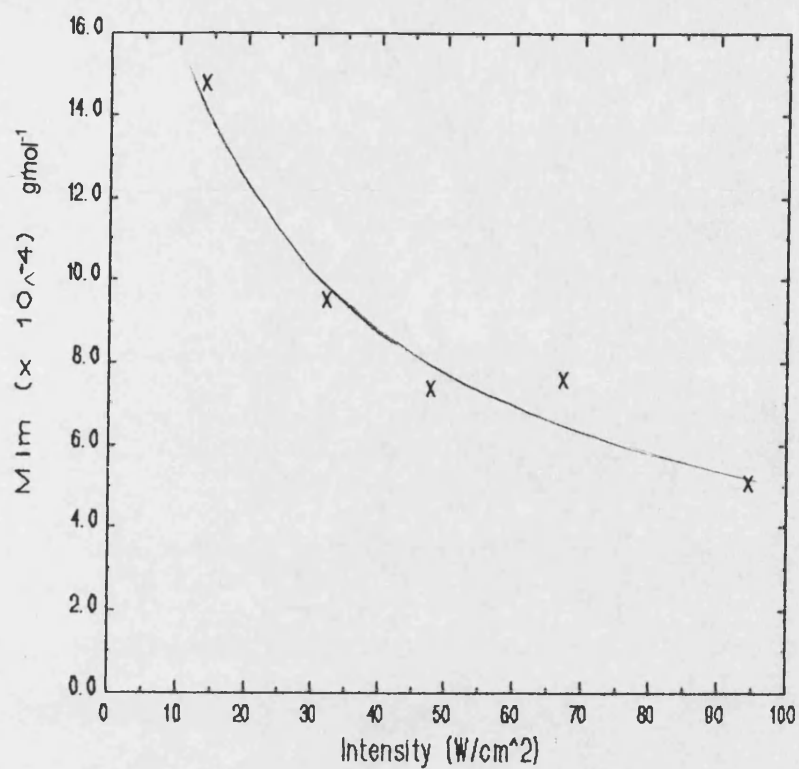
The effect of sonication at various ultrasonic intensities upon  $M_{lim}$
